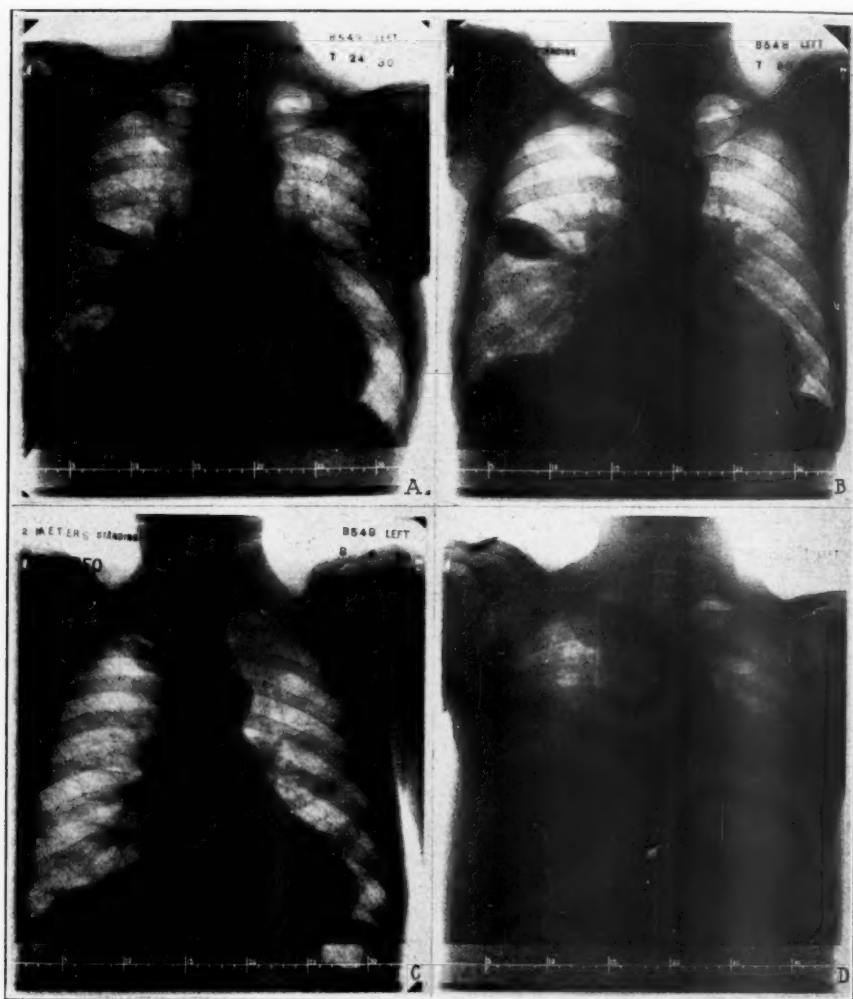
Case I. A. X-ray photograph on admission showing size of interlobar effusion when first seen. B. Six days later—effusion increased with increase in signs of heart failure. C. Showing disappearance of the interlobar fluid six days after administration of digitan. D. Post-mortem x-ray picture showing reaccumulated interlobar fluid.
